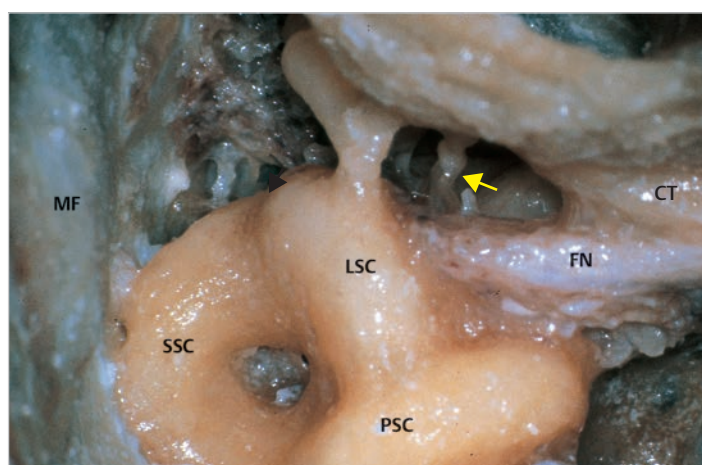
The stapes' superstructure and the incudostapedial joint are seen (arrow). The second genu of the facial nerve is located just inferomedial to the lateral semicircular canal, and just medial to the short process of the incus. The semicircular canals are positioned perpendicularly to each other. The superior semicircular canal is located just beneath the middle fossa dura. CT, chorda tympani; FN, facial nerve; LSC, lateral semicircular canal; MF, middle fossa plate; PSC, posterior semicircular canal; SSC, superior semicircular canal.
